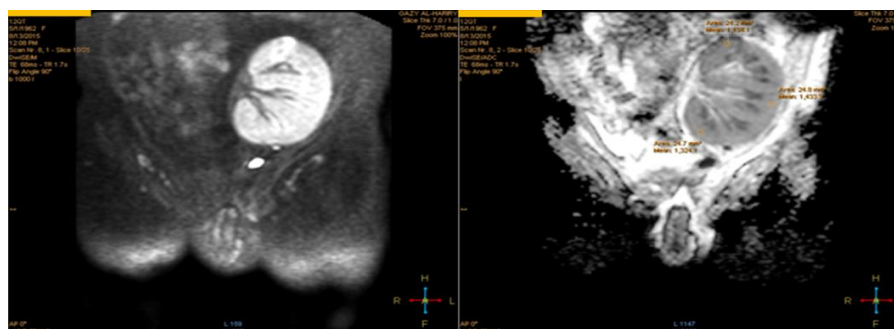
Coronal DWI and ADC for patient with acute renal allograft rejection, the ADC map showing homogeneous pattern with low mean ADC values of renal parenchyma.
